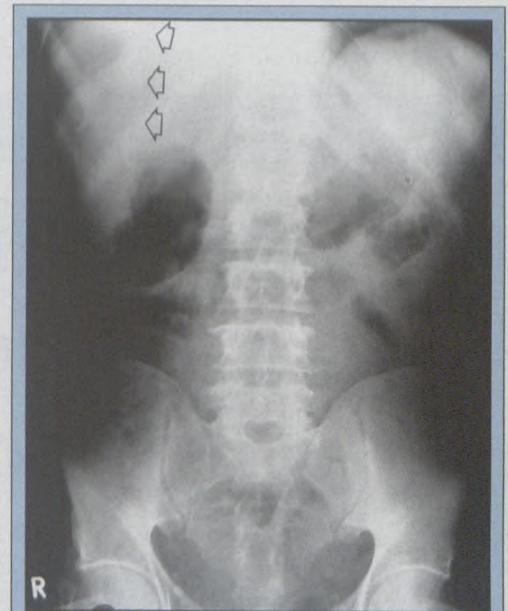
Part of 'football sign' seen overlying liver (arrows) on supine abdominal radiograph, due to intraperitoneal free air which was shown to be subdiaphragmatic in position on chest x-rays. No distended large bowel loops to suggest sigmoid volvulus. The similarity of the 'liver overlap sign' of sigmoid volvulus (Figure 1a) and the 'football sign' of intraperitoneal free air (Figure 2) on supine abdominal radiographs is remarkable.
